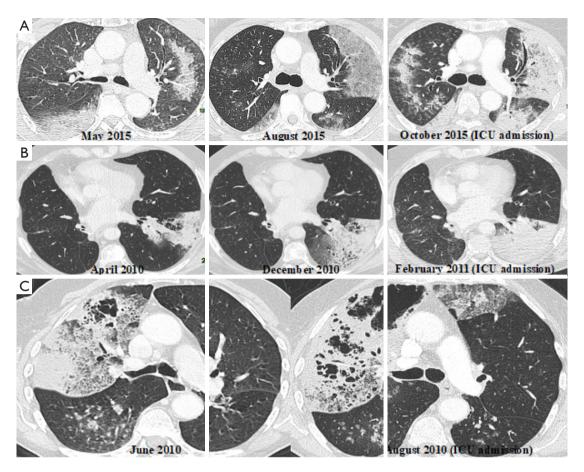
Radiological evolution of diffuse pneumonic-type adenocarcinoma without treatment in three patients (patient A, B and C). Intravenous contrast chest CT-scan in parenchymal windows. Panels A, B and C represent the cancer radiological evolution along time in three distinct patients. Panel A shows a peripheral and bilateral extension of a low-density attenuation, progressing to alveolar consolidation. Panel B shows a peripheral extension of a dense alveolar consolidation. Panel C shows the quick evolution of an excavation process within a 2-month period. Note the presence of a fissural bulging and compressed bronchus in the Panel C. ICU, intensive care unit; CT, computed tomography.
